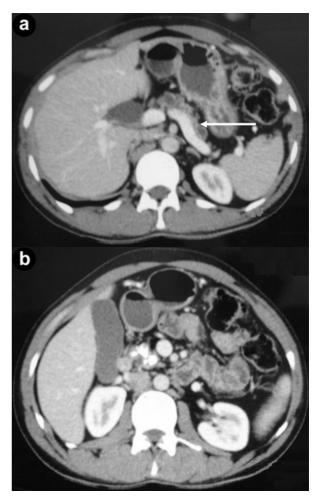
CT showing atrophic pancreas with a dilated (1 cm) pancreatic duct (a. arrow) and calcification at the head and uncinate process of the pancreas (b.).
